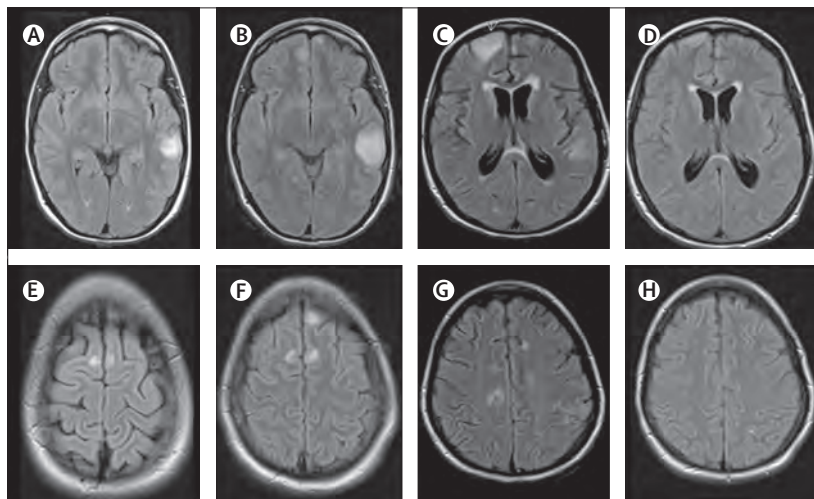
MRI findings in index patient 1
